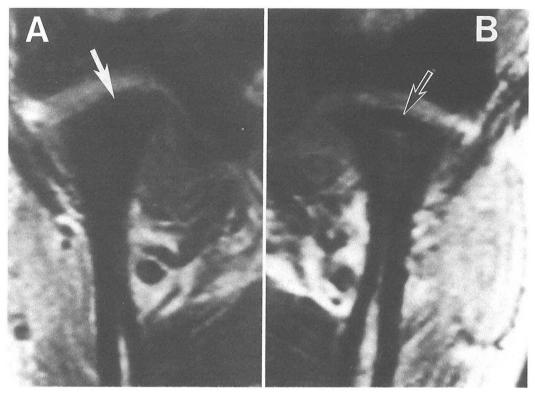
Coronal T1-weighted images (FE 30/13, $\theta = 30^{\circ}$). A, Right TMJ on mouth closing. Low signal intensity was seen in the condylar head (white arrow). B, Left TMJ on mouth closing. A high-signal area surrounded by a low-signal area was observed (black arrow).
